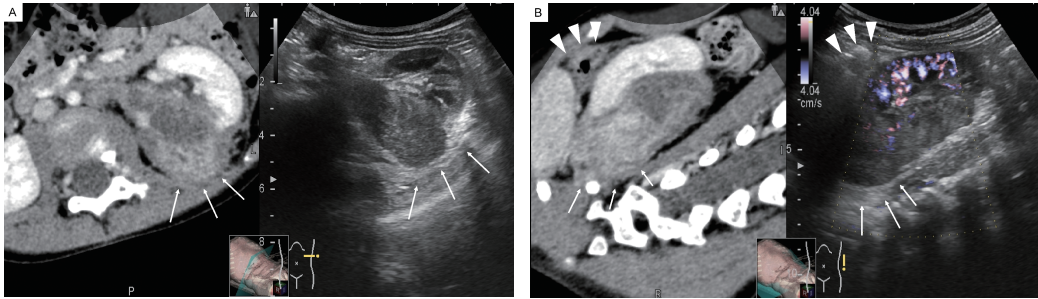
Real-time virtual sonography with computed tomography findings after chemotherapy
